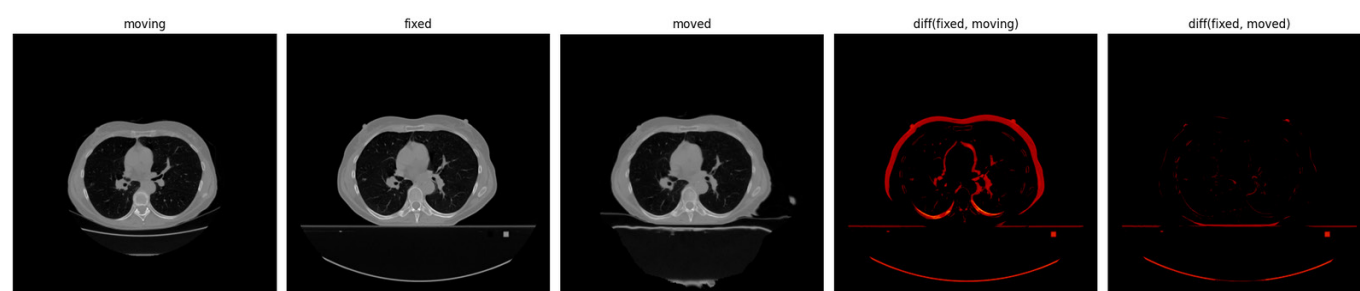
Analysis result – example of the registration result presentation for selected CT scans from both series.
